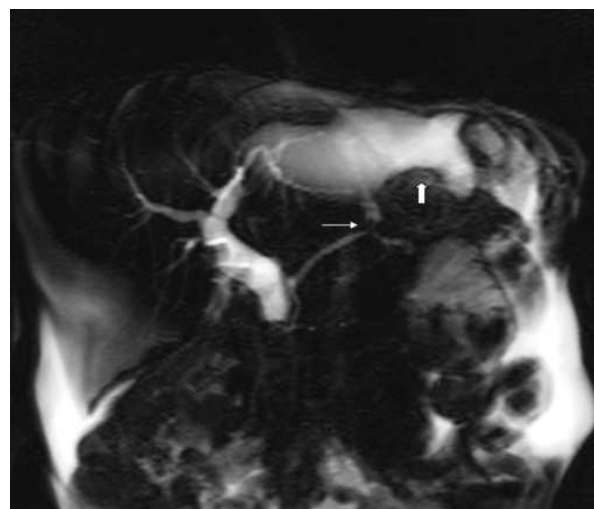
MRI showing a leak from the main pancreatic duct (narrow arrow) into fluid tracking superiorly toward the left pleural space (wide arrow).
